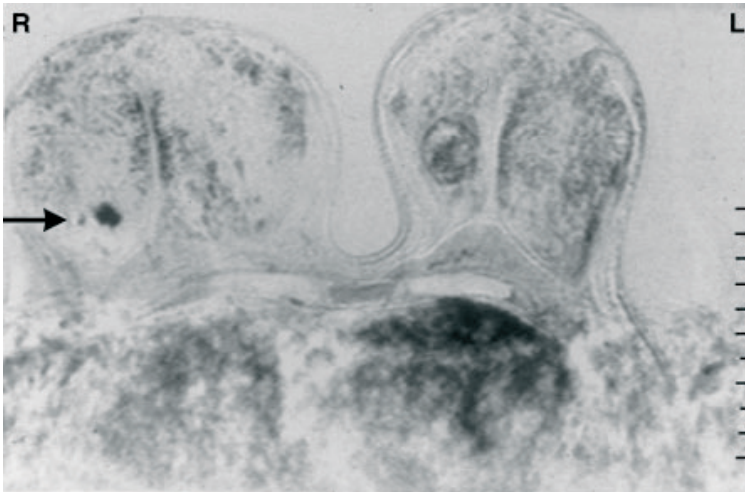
The MRI image after subtraction shows strong irregular enhancement dorsolateral in the right breast in patient B. Medial in the left breast a typical fibroadenoma.
